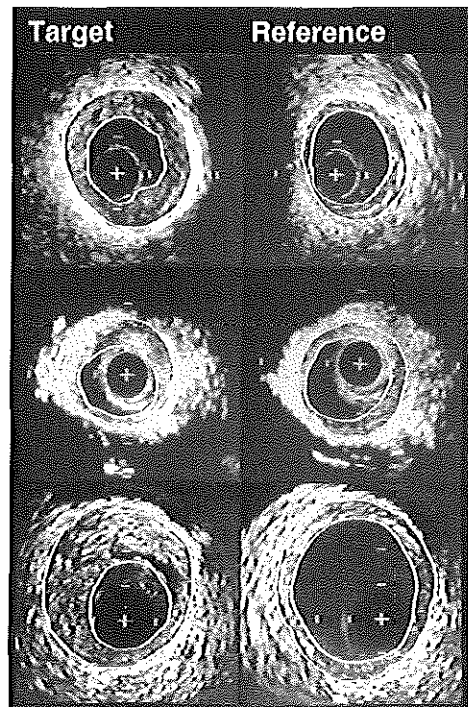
Intravascular ultrasound cross-sections obtained from atherosclerotic coronary arteries showing the target site (left panel) and the reference site (right panel). The inner contour presents the lumen area and the outer contour the vessel area. The vessel area at the target site was larger (upper panel), in the same order (middle panel), and smaller (lower panel) than at the reference site. Calibration = 1 mm; + = catheter.
